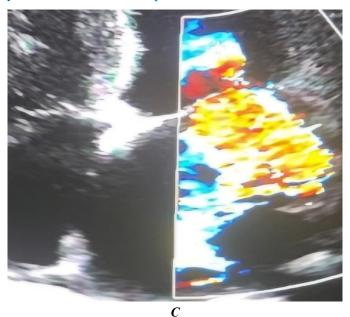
Two-dimensional TTE examination (A) Apical four-chamber view. (B) Apical two-chamber view. Morphologic examination of the mitral valve leaflets in both views revealed leaflet thickening and vegetations on the edges of both leaflets mitral valve. (C) Severe mitral regurgitation with left atrial area (29 cm²)
